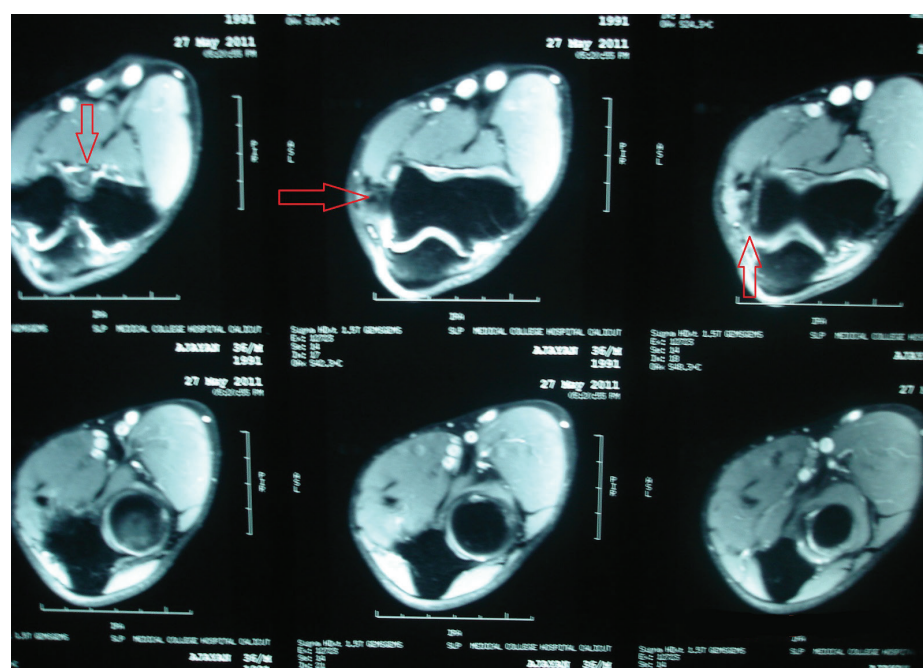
Magnetic resonance imaging of the right elbow coronal section. T1-weighted images showing multiple hypointense loose bodies.
